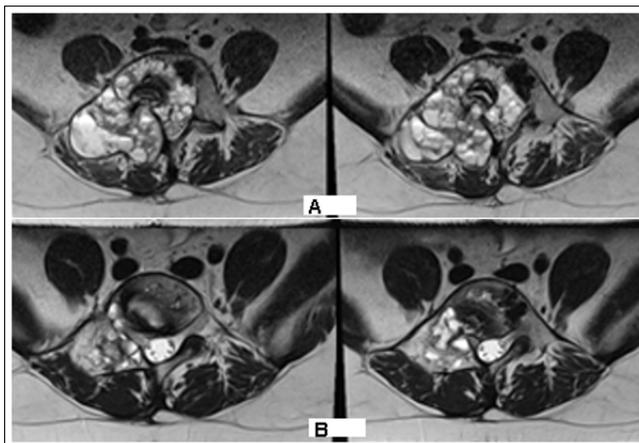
A/ Comparison of MRI Before IMRT/ a and after 1 Year from IMRT/B
